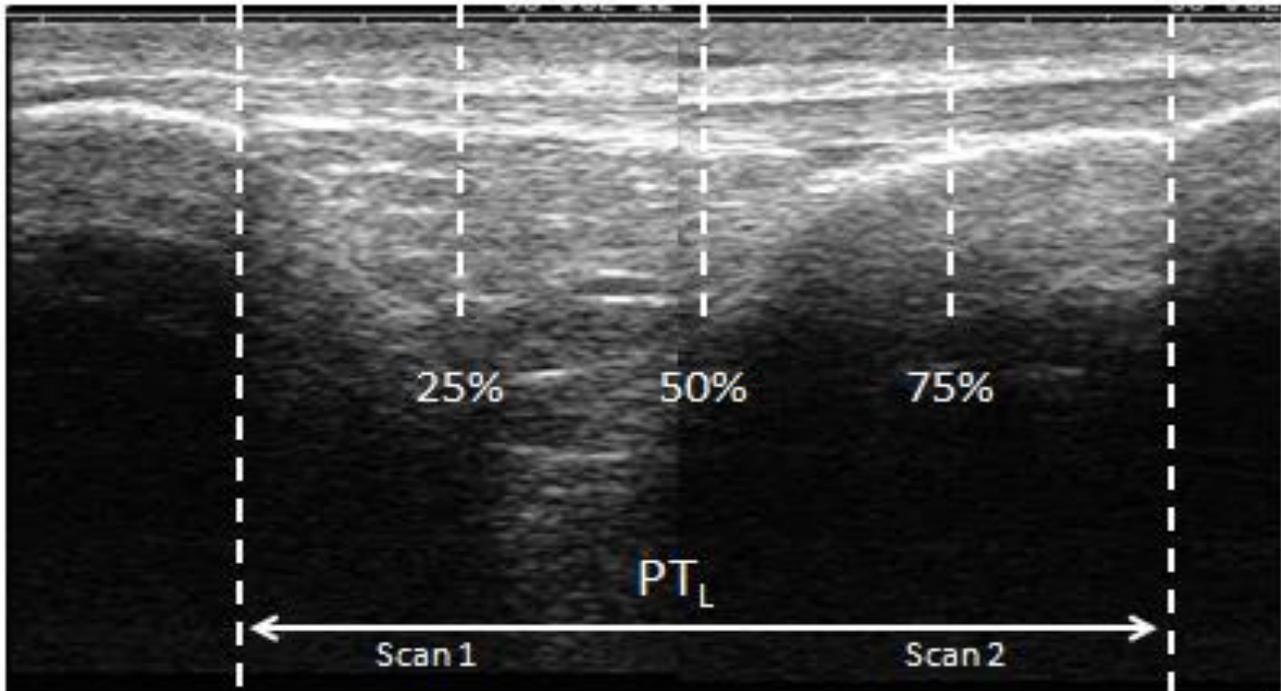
Shows a sagittal plane ultrasound image of a study participant (composed of 2 scans) of the patella tendon denoting measurement locations of tendon cross-sectional areas (knee at 90° flexion).
